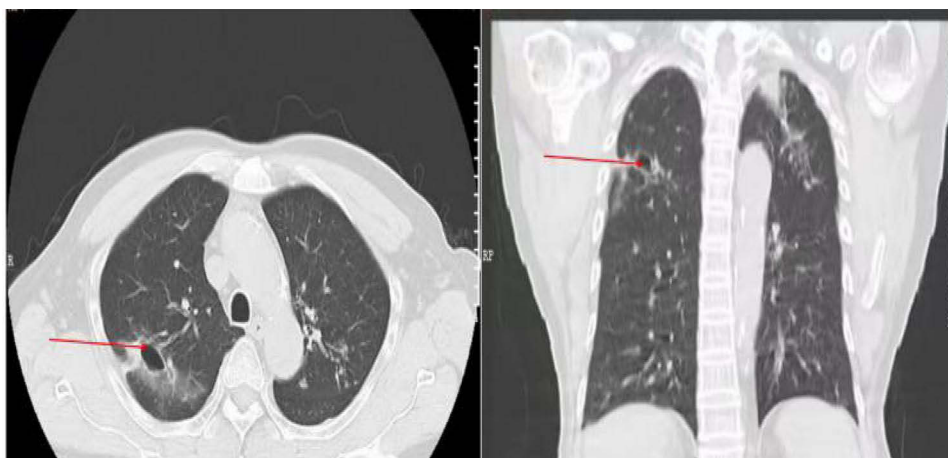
The chest CT scan depicted substantial improvement following the administration of treatment, showing largely resolved mottled streaks and flaky dense material in various regions. Specifically, these improvements were noted in the apical posterior, lingual, dorsal lower lobe, and posterior basal segments of the left lung, as well as in the apical, anterior, posterior, middle, dorsal, anterior, and medial basal segments of the right lung. Furthermore, shrinking cavities were observed in the apical posterior, lingual, dorsal lower lobe, and posterior basal segments of the left lung. Red arrows were used to denote cavities.
